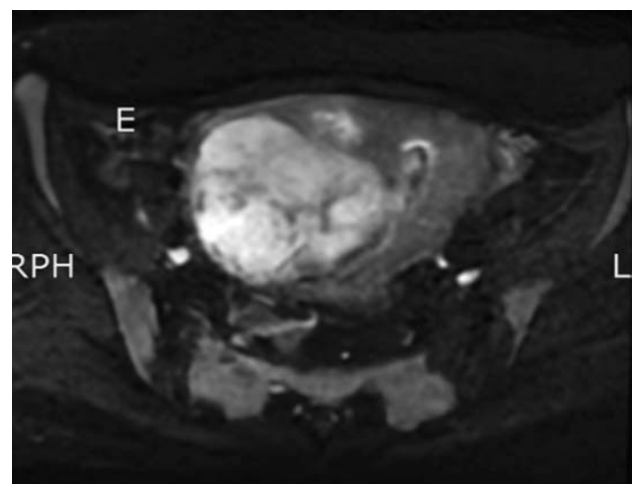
MRI pelvis: Image A and B (T2 axial and sagittal) demonstrate a well-defined heterogeneously hyperintense lobulated lesion with indistinct inferior margin originating from right lateral wall of uterus, extending medially and submucosally, protruding into the endometrial cavity, extending inferiorly, causing widening of the cervical canal and hanging into the vagina. It was pushing the endometrium towards the left side.
